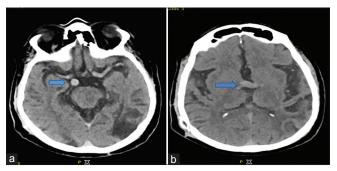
Computed tomography of the brain (arrows in a and b) shows dilated and tortuous vertebrobasilar arteries
